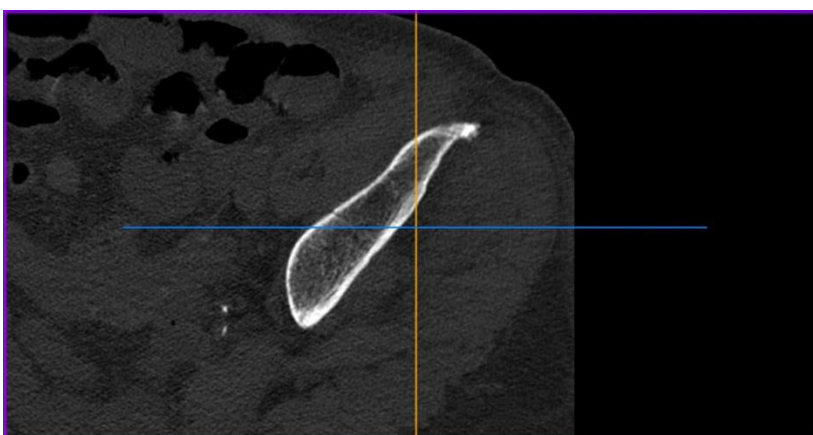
CT scan (axial section) reveals a compound fracture of the iliac wrist extending to the acetabular column
